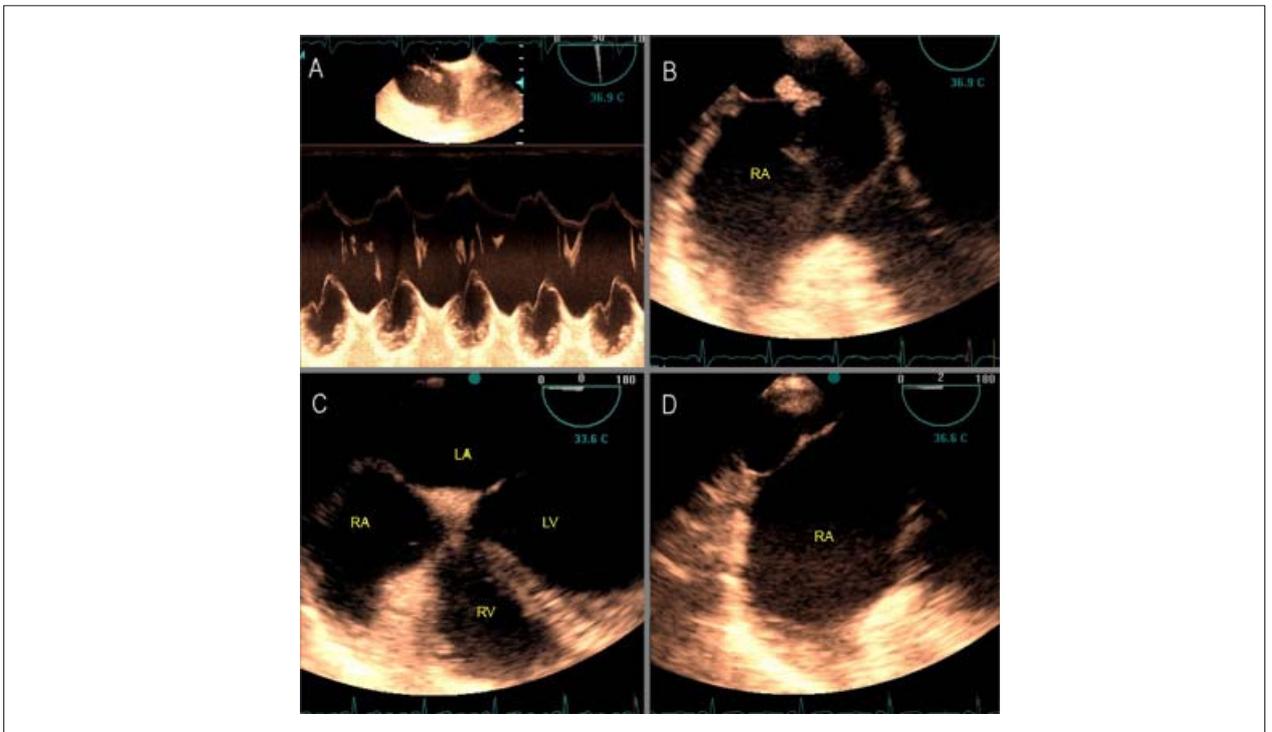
Transesophageal echocardiogram, showing: A - M-mode structure with ample movement; B - thrombus adhered to Eustachian valve; C and D - post-treatment showing 4 chambers and Eustachian valve without thrombus, respectively; LA - Left atrium; LV - Left ventricle; RA - Right atrium; RV - Right ventricle.
